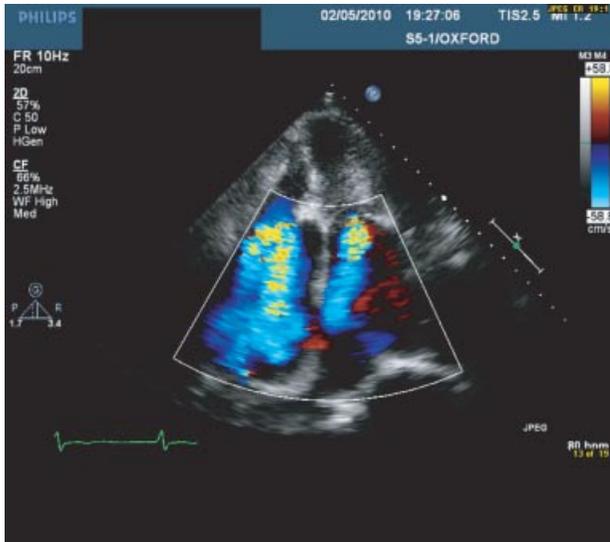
Apical five-chamber TTE view demonstrating a wide jet of severe aortic regurgitation in the left ventricular outflow tract extending to the left ventricular apex.
